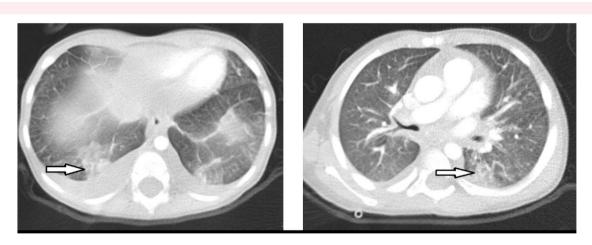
Computed tomography sections demonstrating focal areas of consolidation (arrow), consistent with septic pulmonary infarcts.
